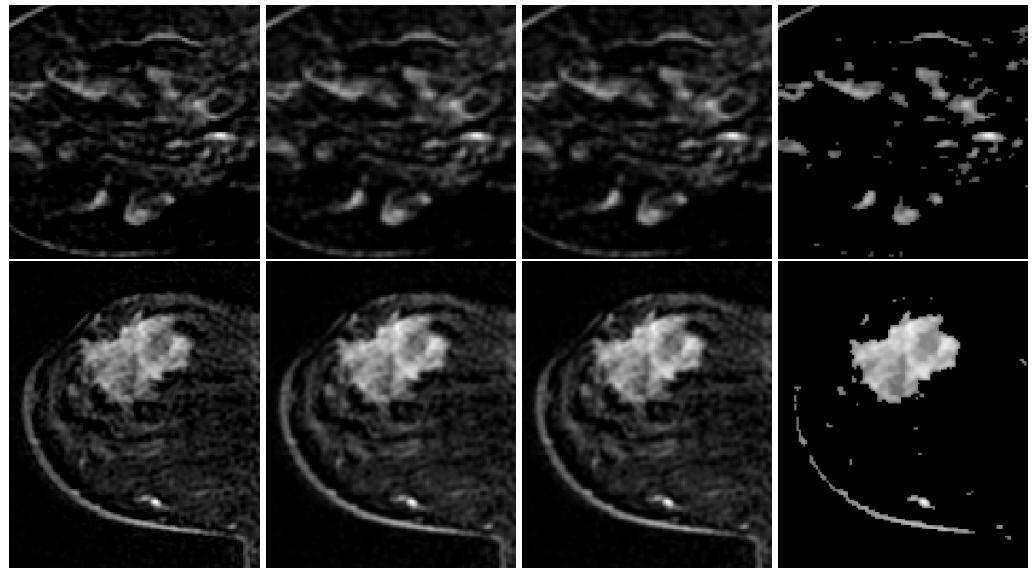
Examples of pre-processing steps on two breast lesions (one per row): (1st column) DCE-MRI breast image (after cropping); (2nd column) Gaussian smoothing result; (3rd column) centering result; and (4th column) gamma correction result. With respect to the position in the DCE-MRI sequence, all images have been rotated 90° clockwise, in order to improve the graphic representation and allow all the images relating to a specific lesion to be displayed in a single line.
